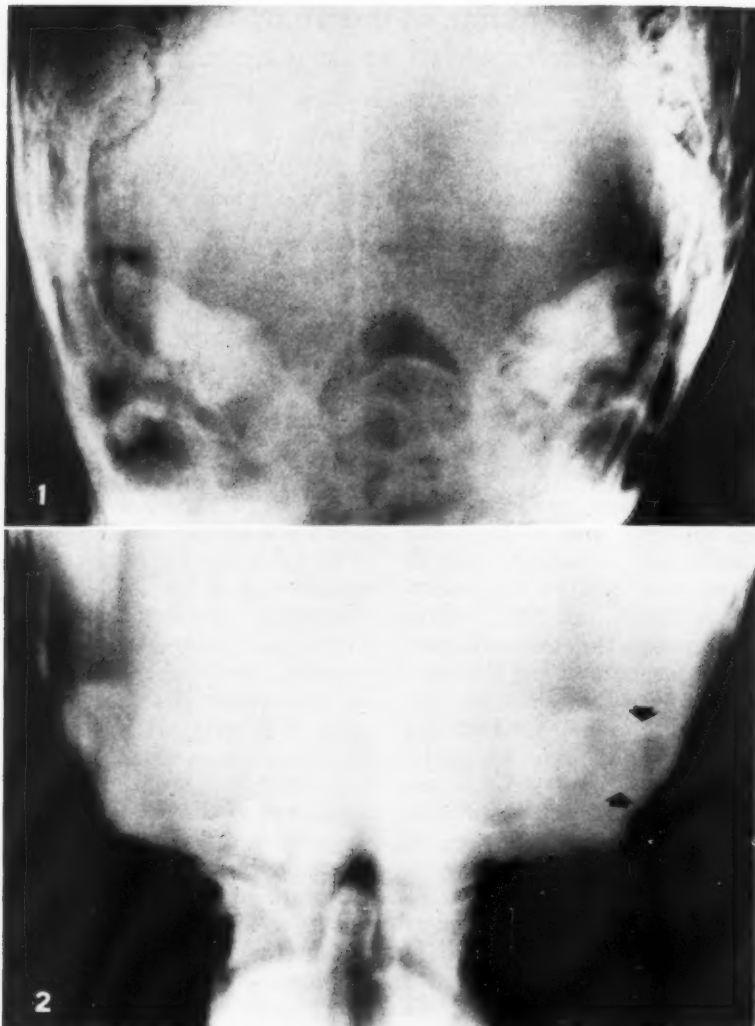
Preoperative roentgenogram of a nineteen-year-old male with chronic bilateral middle-ear infection, demonstrating sclerotic mastoids with a poorly defined lytic defect in the region of the left mastoid antrum. Because of difficulty in measuring the extent of the defect, tomography was done. See Fig. 2.
